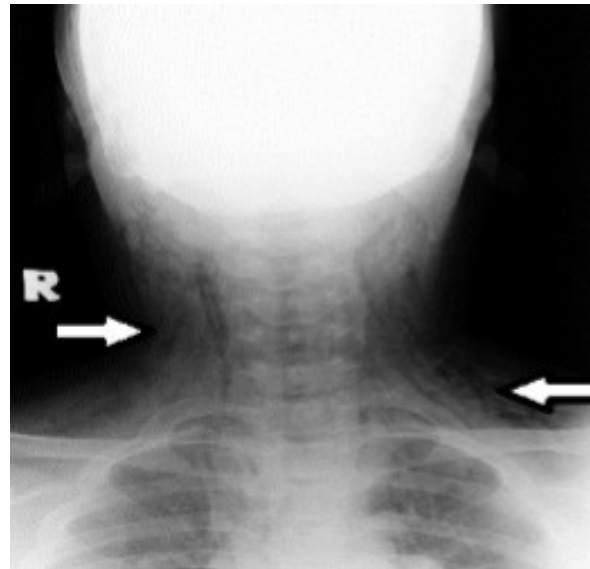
Post-operative day 2 AP view of soft tissue neck radiograph. Arrows show bilateral supraclavicular subcutaneous emphysema.
